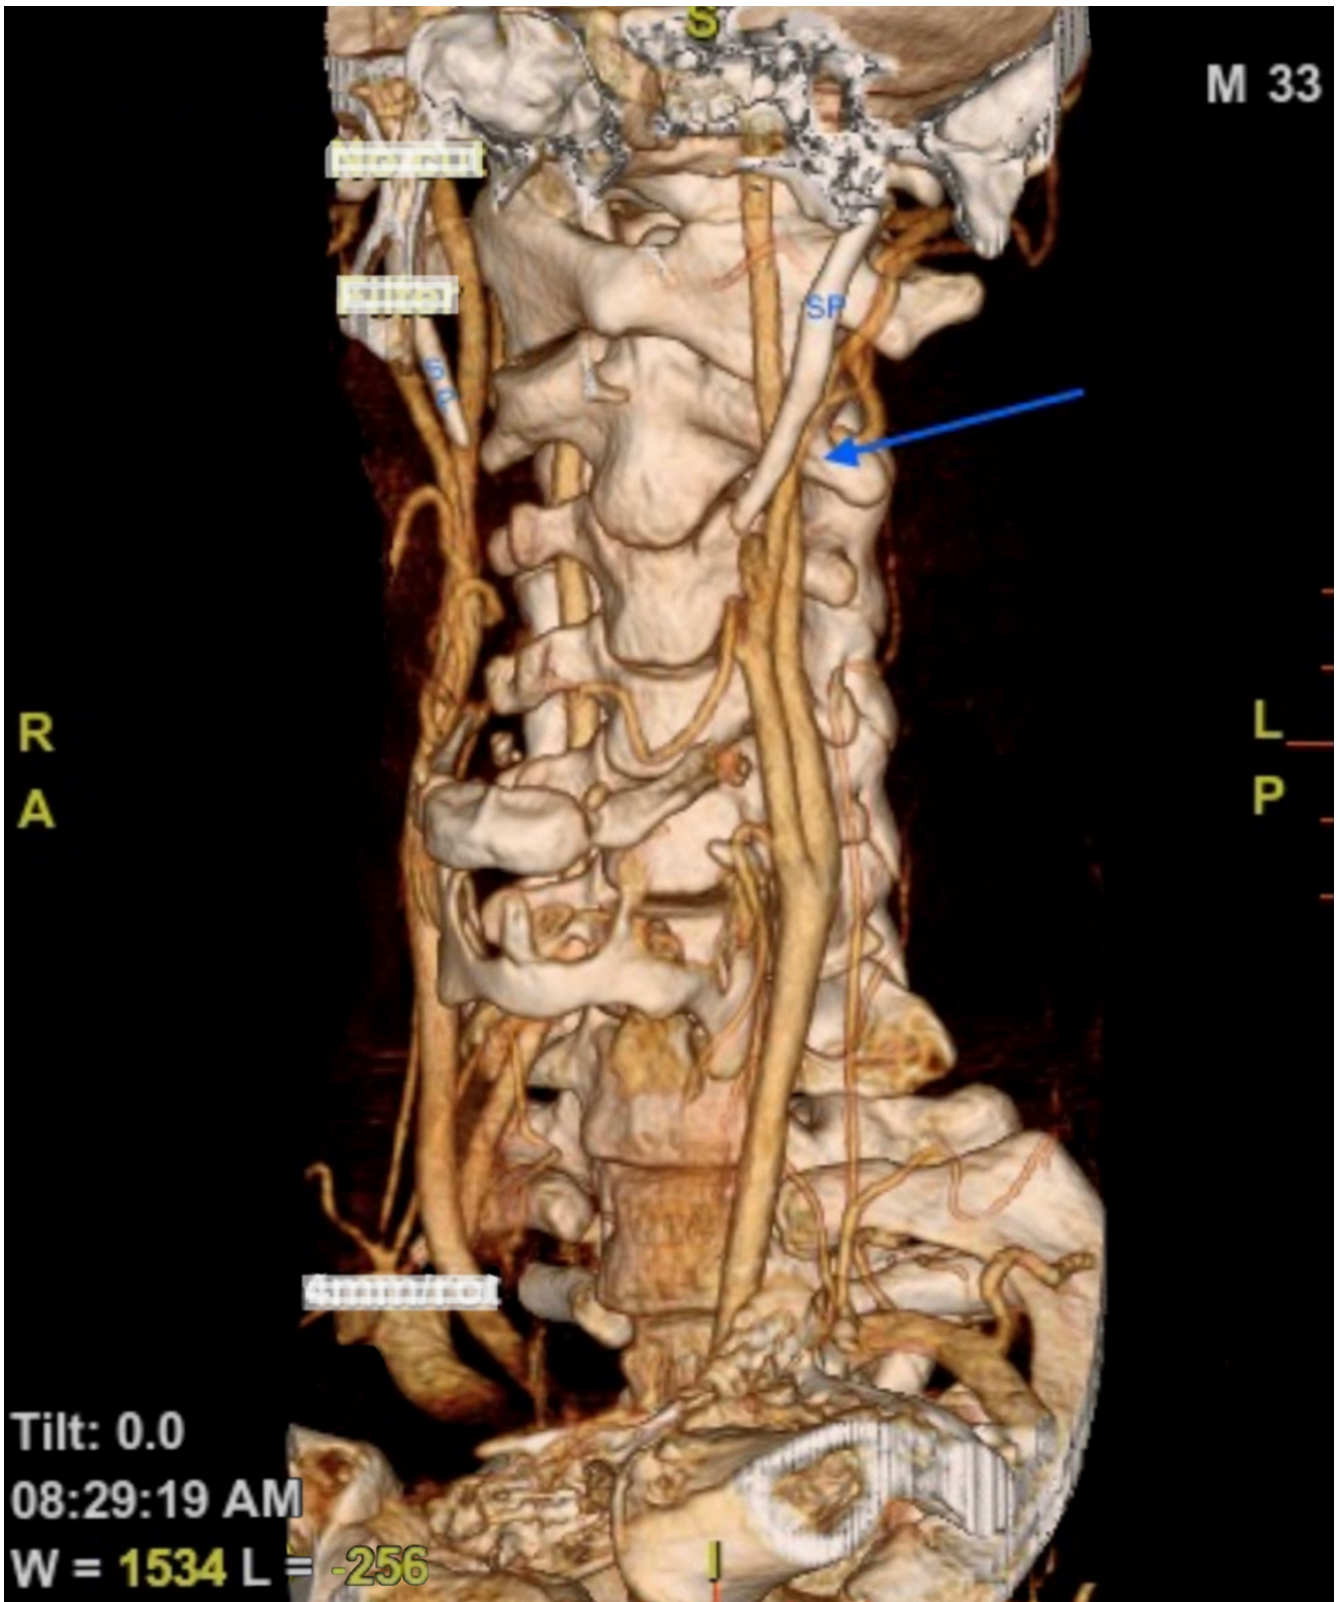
CT-angiogram showing bilateral elongated styloid processes, with carotid artery impingement (blue arrow); SP: styloid process.
